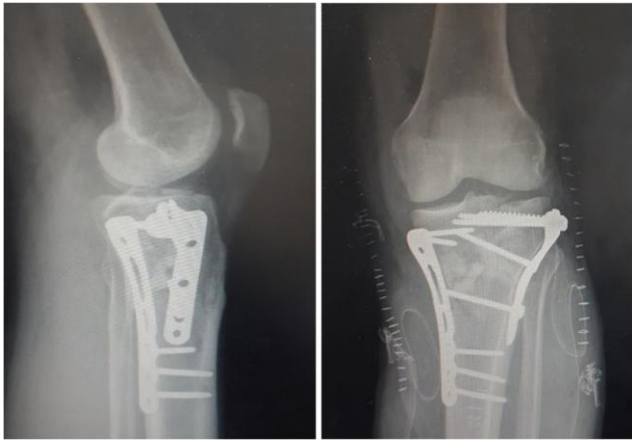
Clinical case: 40-year-old patient. Closed Schatzker 6 TPF. Post-operative x-rays
